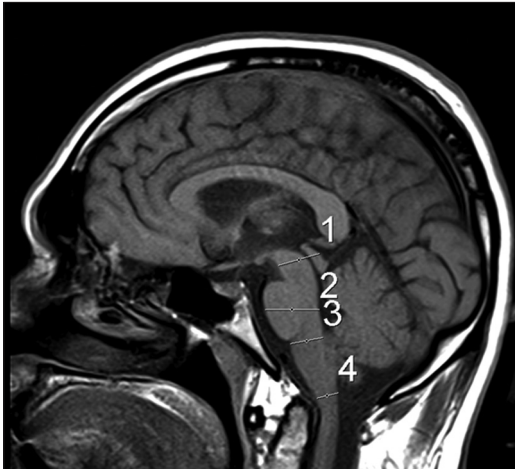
MRI of the brain T1-weighted sagittal image demonstrating midsagittal anteroposterior diameters of the midbrain (1), pons (2), medulla at the pontomedullary junction (3), and medulla at cervicomedullary junction (4), respectively. MRI: Magnetic resonance imaging
